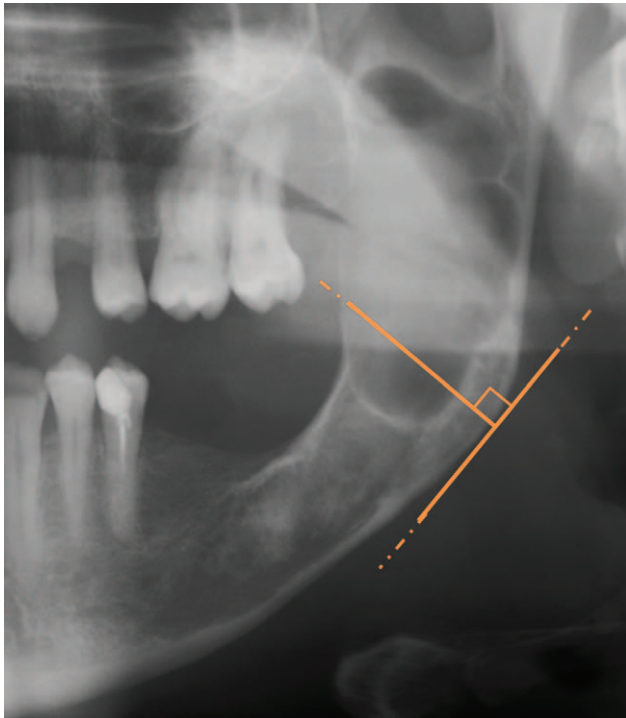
Orthopantomogram radiography showing keratocysts odontogenic tumor crossing an imaginary line perpendicular to the tangent straight at gonion.
